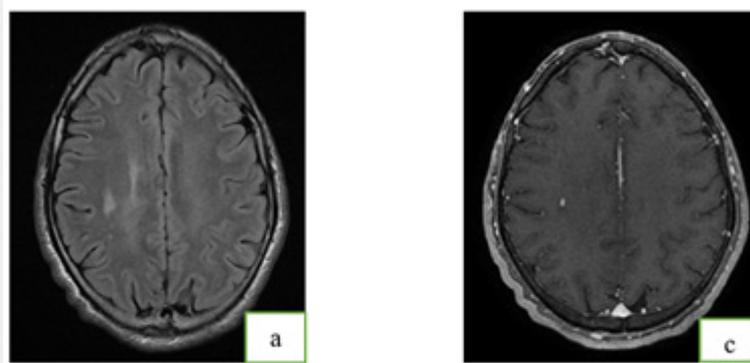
Brain MRI in axial cut T2 FLAIR (a) objectifying signal abnormalities of the SB on the above tensorial floor in relation to OBNI with detection of micronodular contrast after injection of Gado (b).
